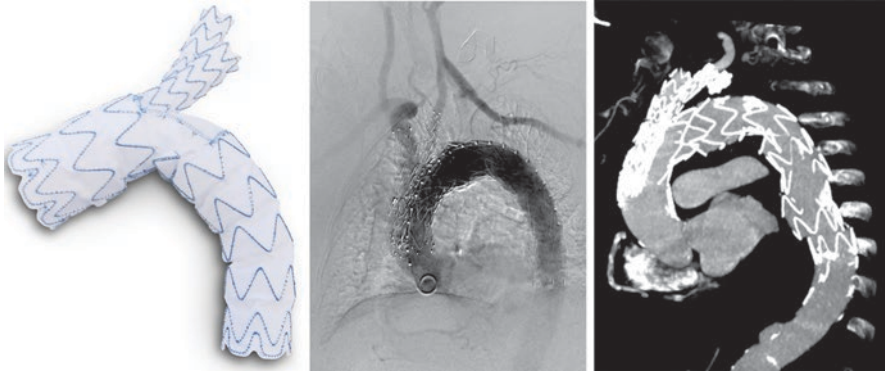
Aortic arch stent-grafting using a dual branch device. A Terumo Aortic dual branch platform was used (Left panel). The branches were deployed in the innominate artery and the left carotid artery. Note the revascularization of the left subclavian artery using a carotid-subclavian bypass graft (Middle panel). Postoperative CT angiogram (Right panel)
